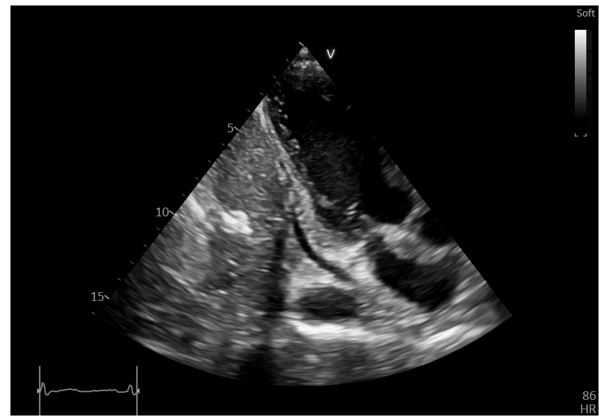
Echocardiography at the initial evaluation (apical three chamber view) showing the atrial mass extension to the anterior wall of the left atrium, with a noticeable thickened appearance. HR, heart rate.
